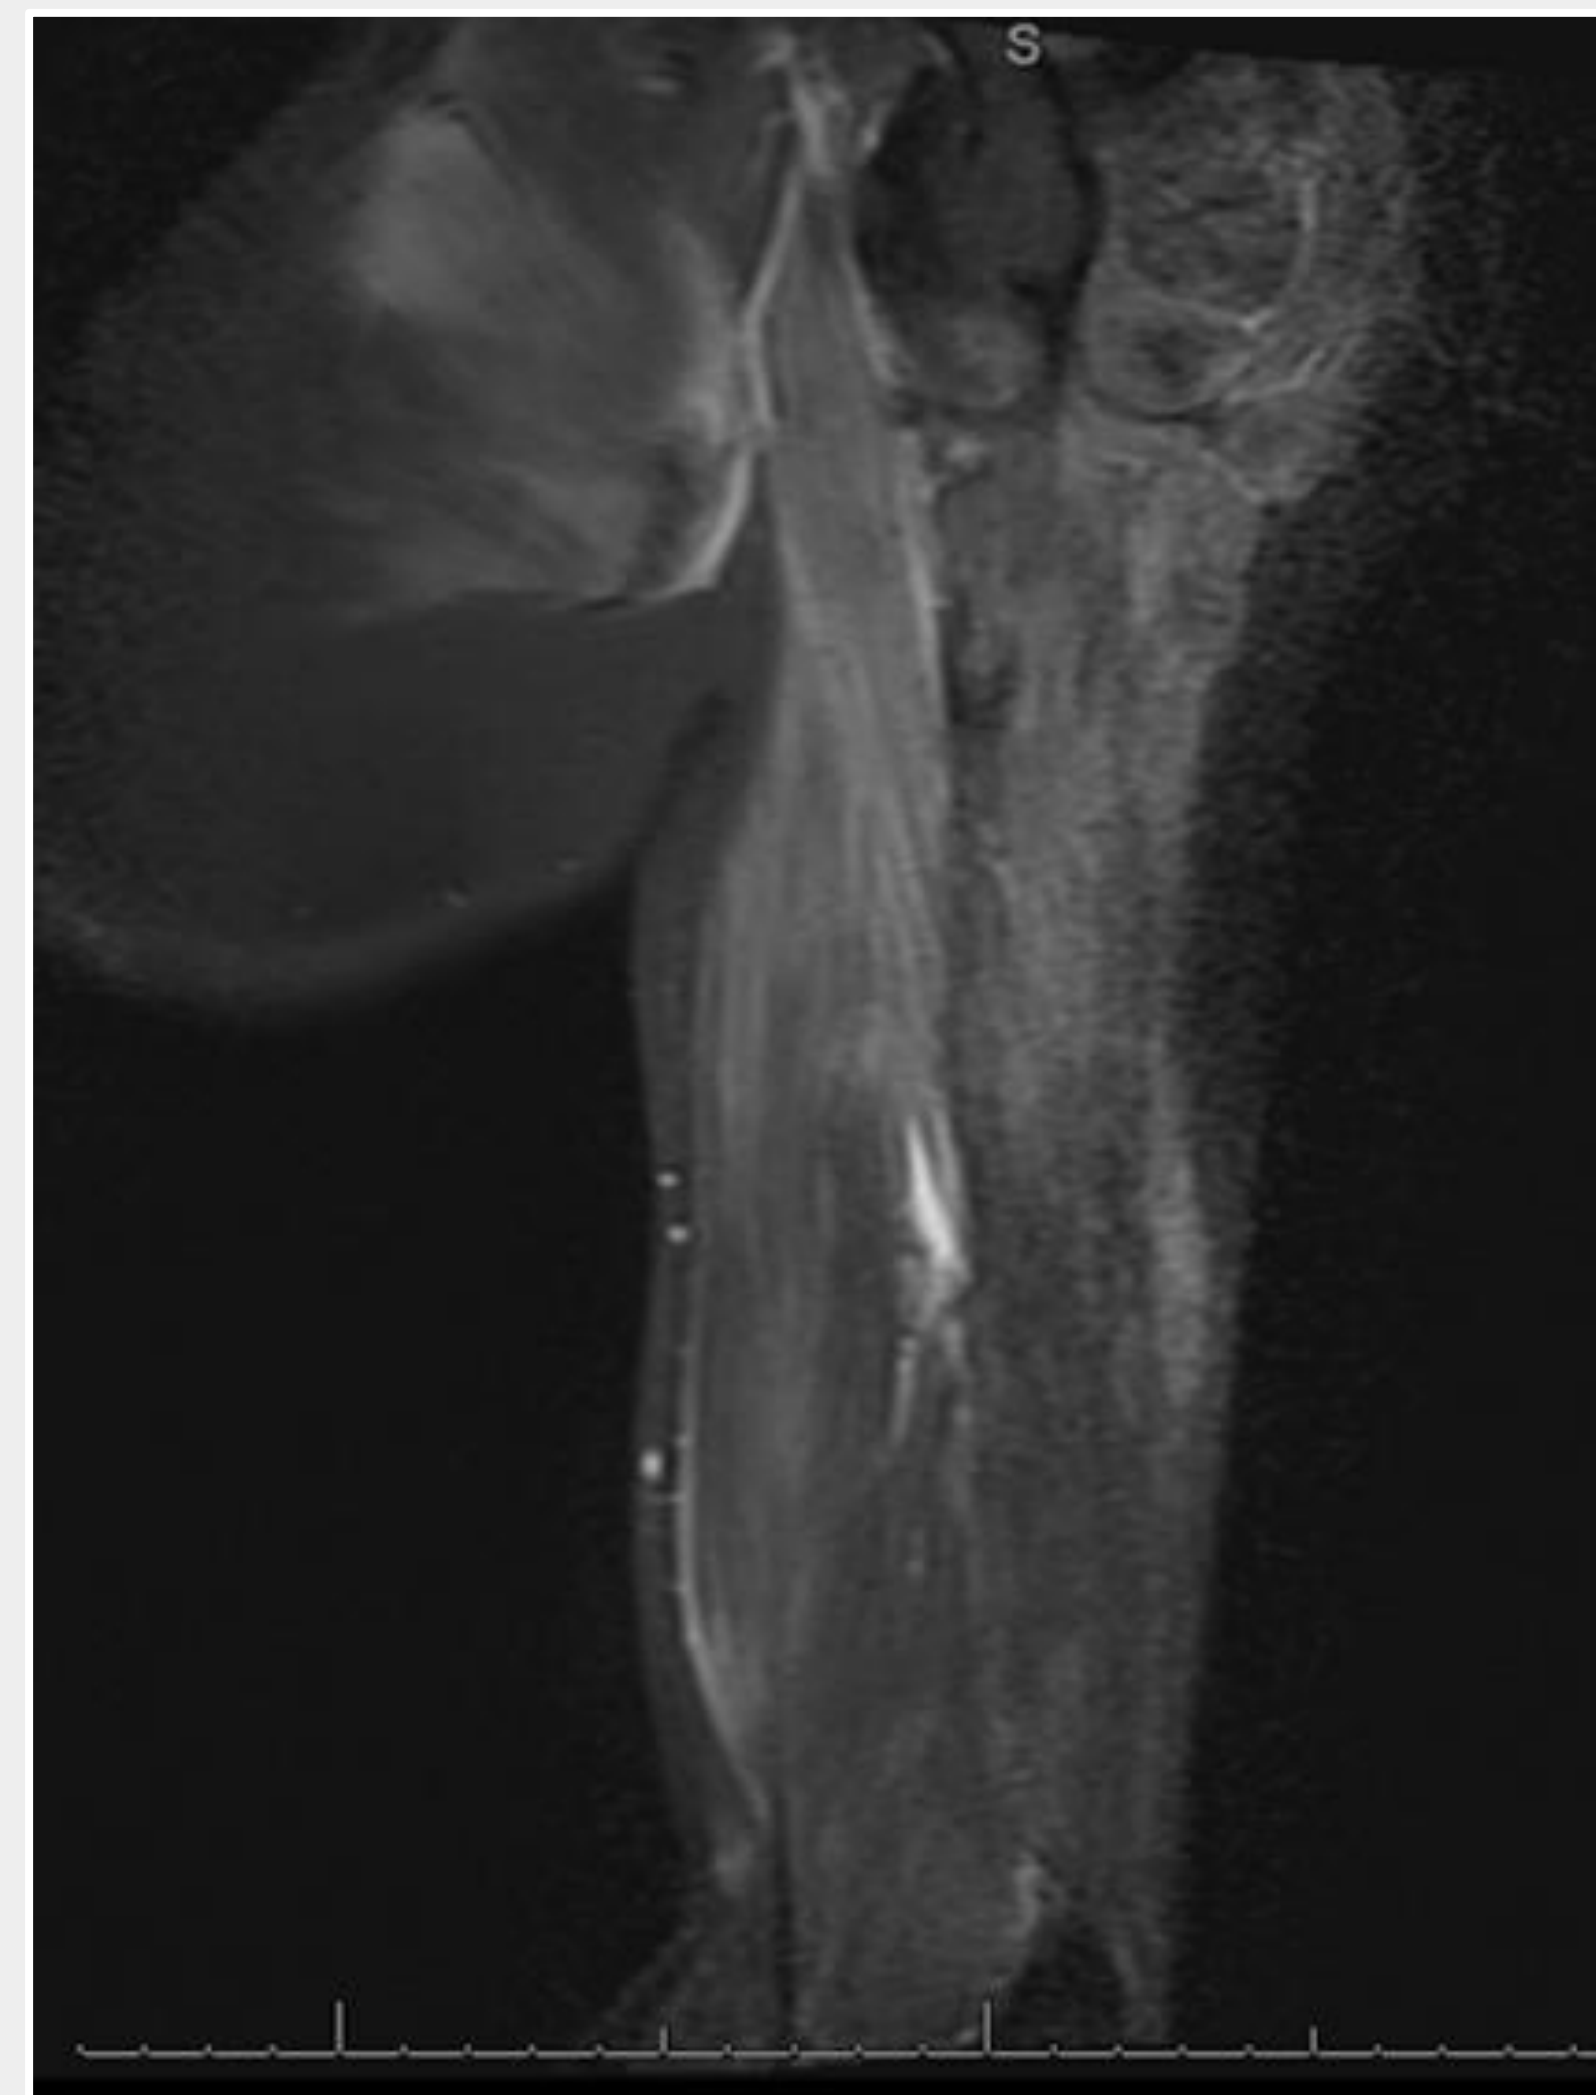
MRI of left upper extremity on admission showing diffuse myositis
